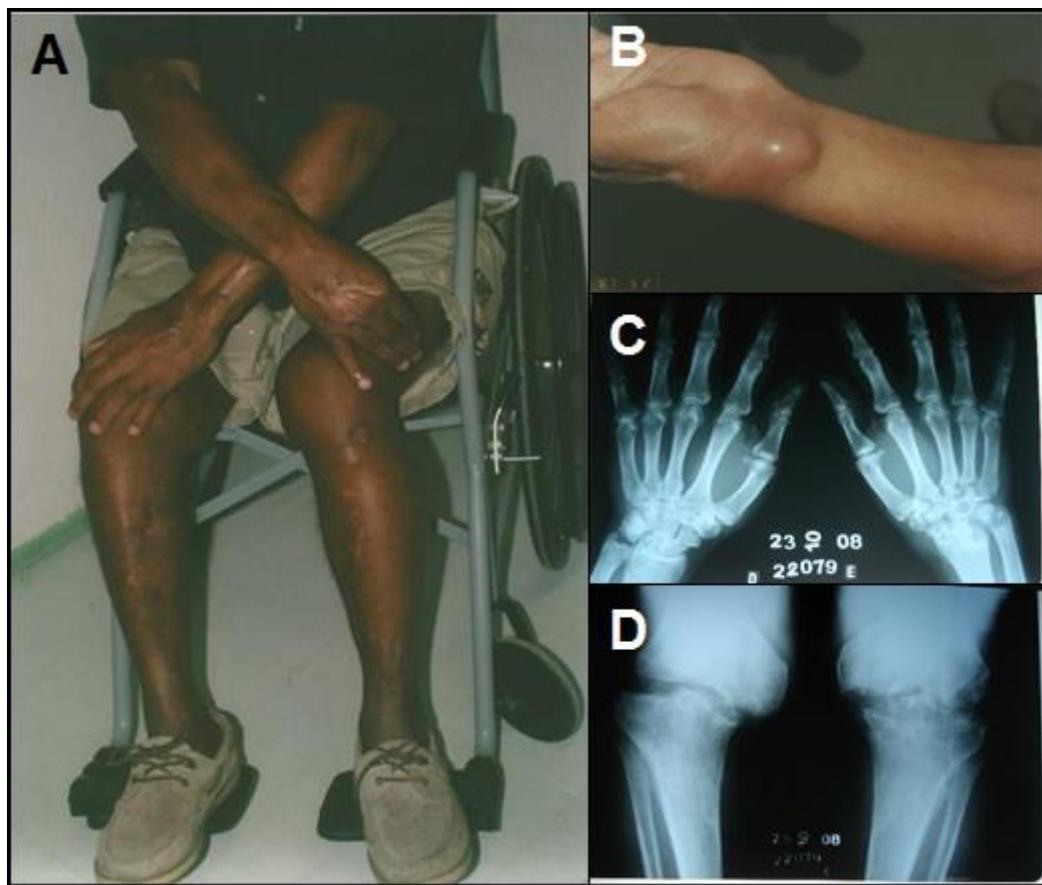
A) Multiple scars on the limbs, where previously the cutaneous lesions were. B) Inflammatory cyst on the left wrist. The first three isolates were collected from that lesion, by puncture with fine needle in different time points, across six months. C-D) Radiographs showed lytic lesions and sclerosis at the left wrist and knees.
